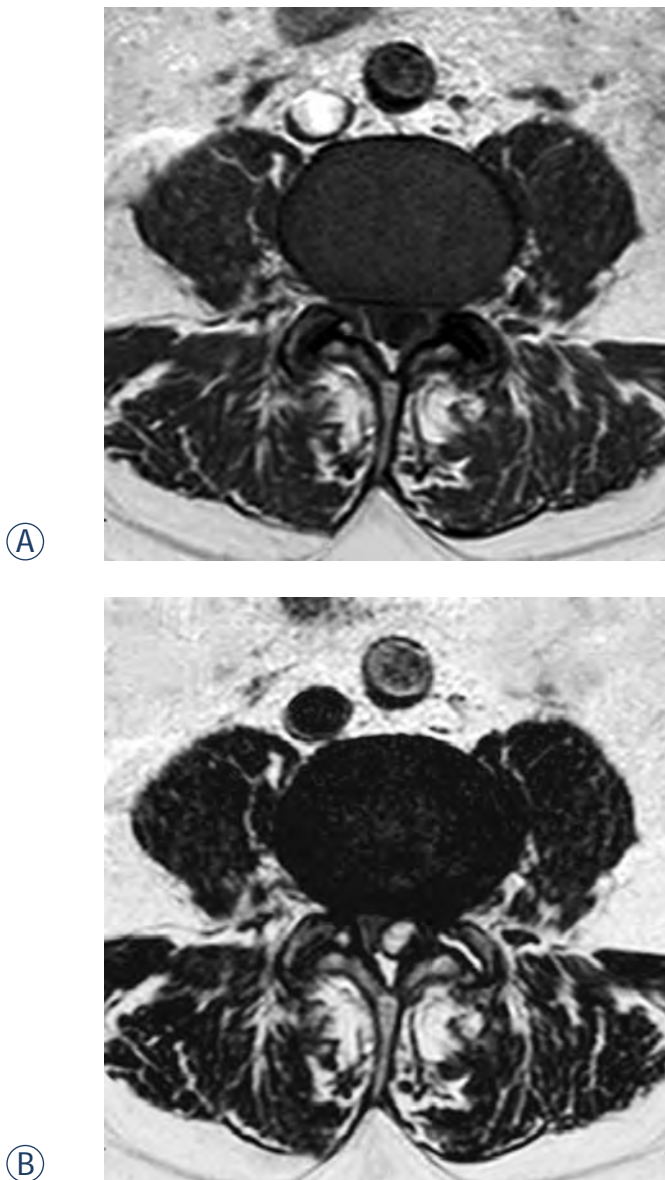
Baseline (preprocedural) MRI in an axial plane at the level of the L4-L5 lumbar segment. Hypointense well delineated cystic formation compressing dural sac from the left dorsolateral side is seen on T1 SE image (A). The cyst that is hyperintense on T2 FSE image shows continuation with the left facet joint (some fluid can also be seen in the degenerated facet joint) (B).
